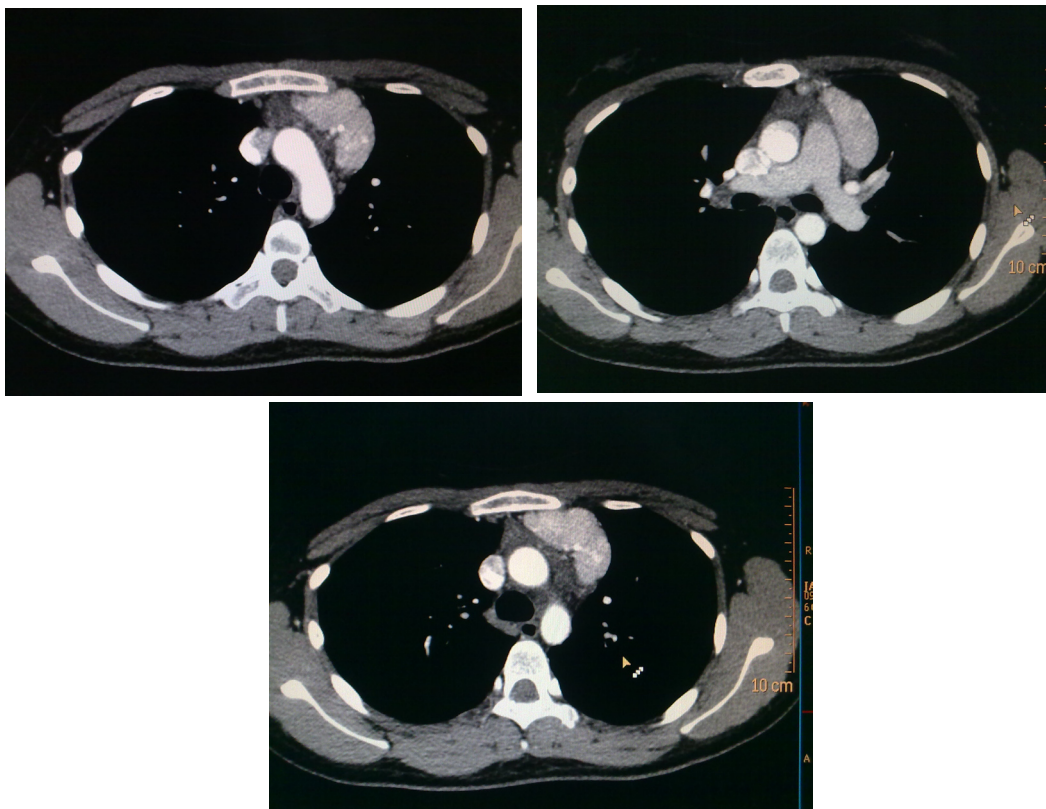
Chest CT scan images of the same patient showing an intensely enhancing, non-calcified, lobulated mass, measuring approximately 2.4 x 5.9 x 6.7 cm (AP x W x CC) in the left anterior mediastinum at the level of the aortic arch extending to the left lateral aspect of the main pulmonary artery.
